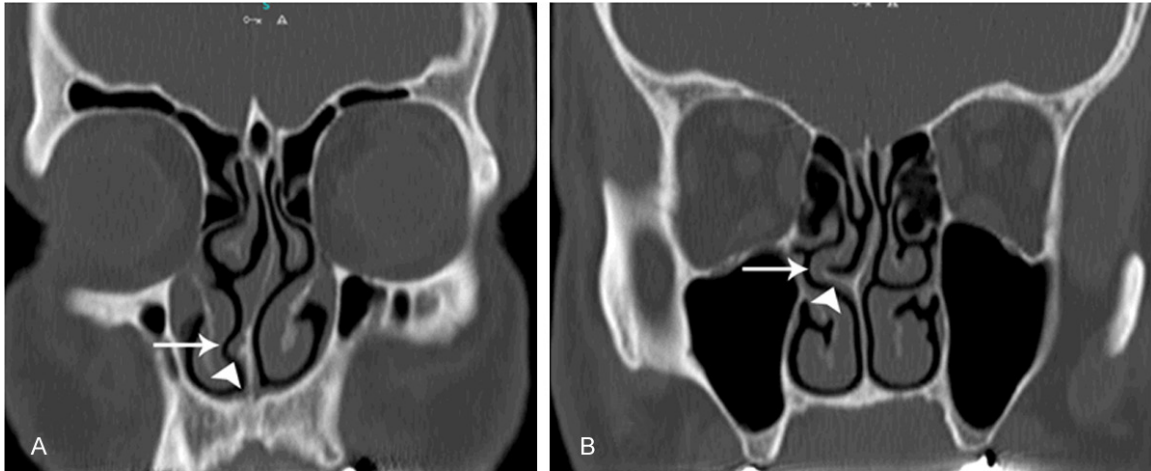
A 48-year old male patient. Coronal CT multiplanar reformation images of paranasal sinus show right inferior (A) and middle concha compression (B) syndrome due to nasal septal spurs which put pressure on inferior and middle turbinates (arrows) and create concha ondularis.
